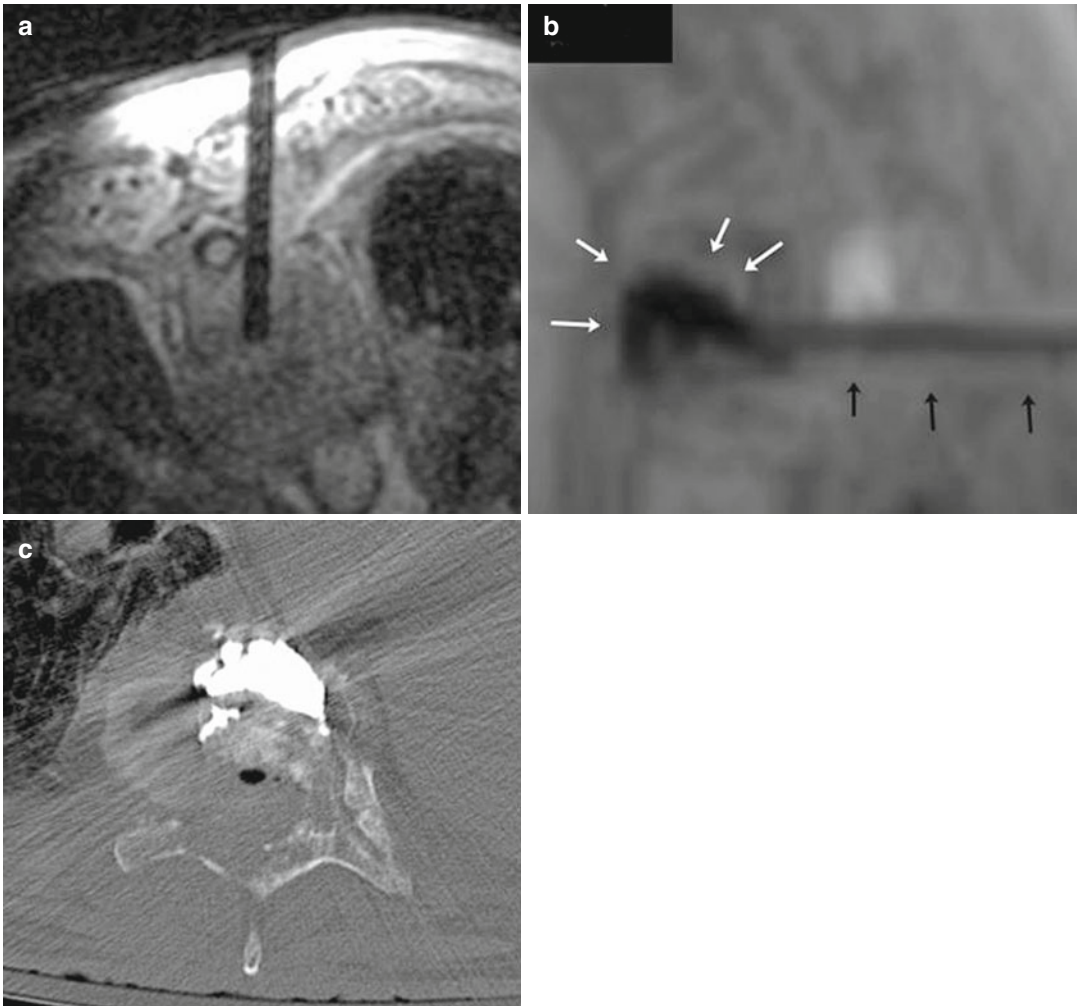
(a-c) MR-guided vertebroplasty using an open-bore low-field MR scanner. The transpedicular puncture path is clearly visible on the axial MR section (a). Tantalum opacified cement injection (*white arrows*) is performed under real time MR imaging using small aliquots of 0.5 ml per injection (b). MRI (sagittal T1 reconstruction) shows cement distribution. *Black arrows* show
